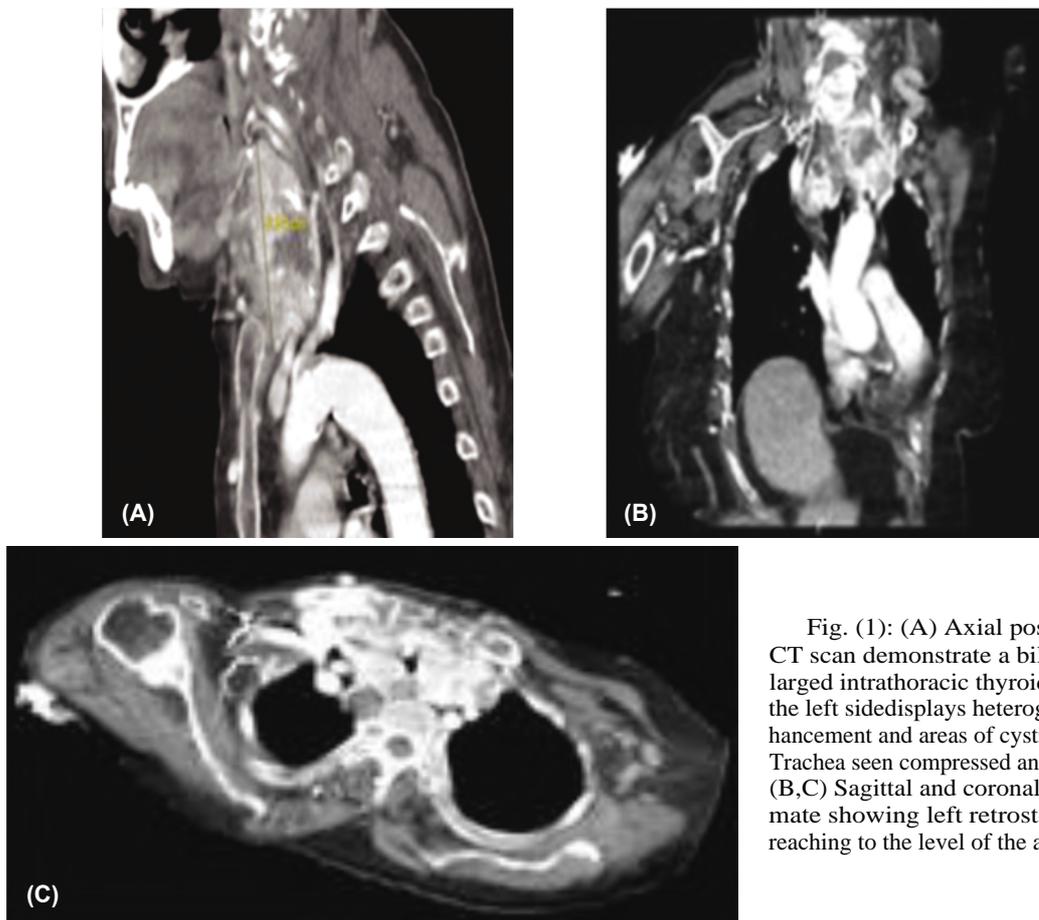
(A) Axial post contrast CT scan demonstrate a bilateral enlarged intrathoracic thyroid, more on the left side displays heterogenous enhancement and areas of cystic changes. Trachea seen compressed and deviated. (B,C) Sagittal and coronal CT reformate showing left retrosternal lobe reaching to the level of the aortic arch.
